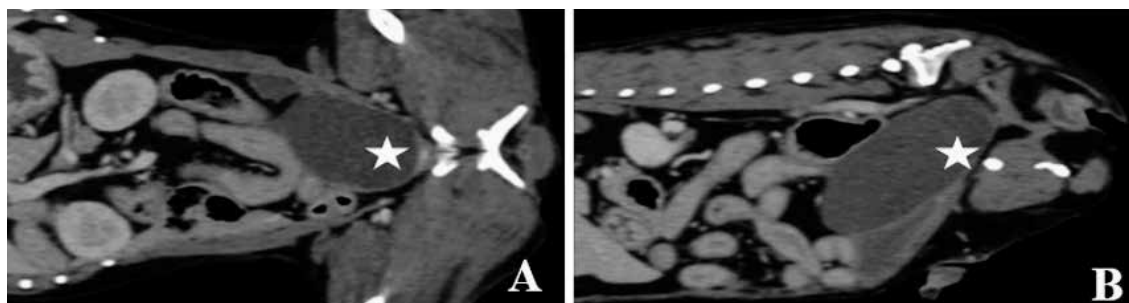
Coronal (A) and sagittal (B) computed tomography (CT) pictures of the abdomen. Cranial is left in the images. There is a large fluid-filled tubular structure visible in the caudal abdomen (white star), located between the descending colon and urinary bladder with a moderate mass effect.
